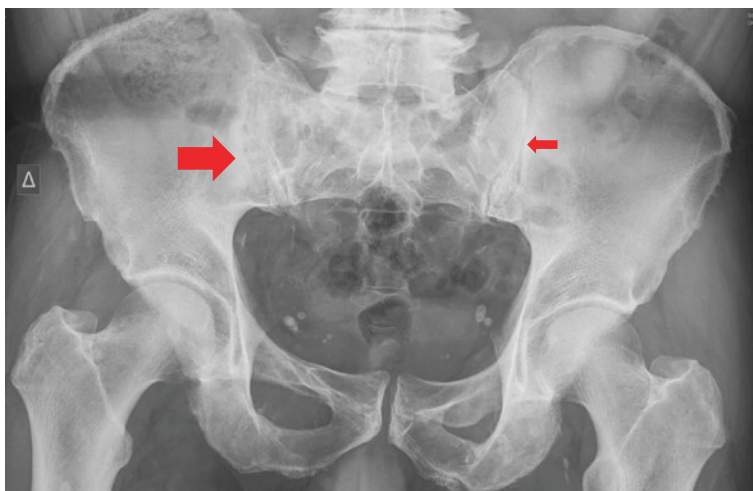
Radiographic findings – sacroiliac joints
